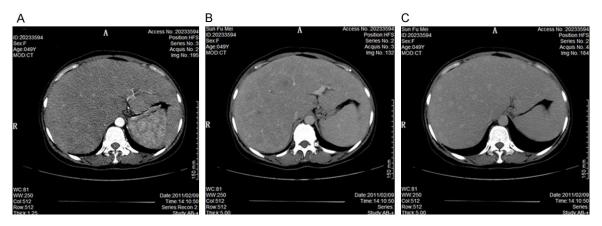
Contrast-enhanced abdominal CT image. A. Heterogeneous enhancement of nodules of varying sizes in an enlarged liver is observed on hepatic arterial phase scan. B and C. On portal venous and delayed phase scan, an attenuated lesion with ambiguous margins is observed accompanying by presence of minimal ascites surrounding the liver.
